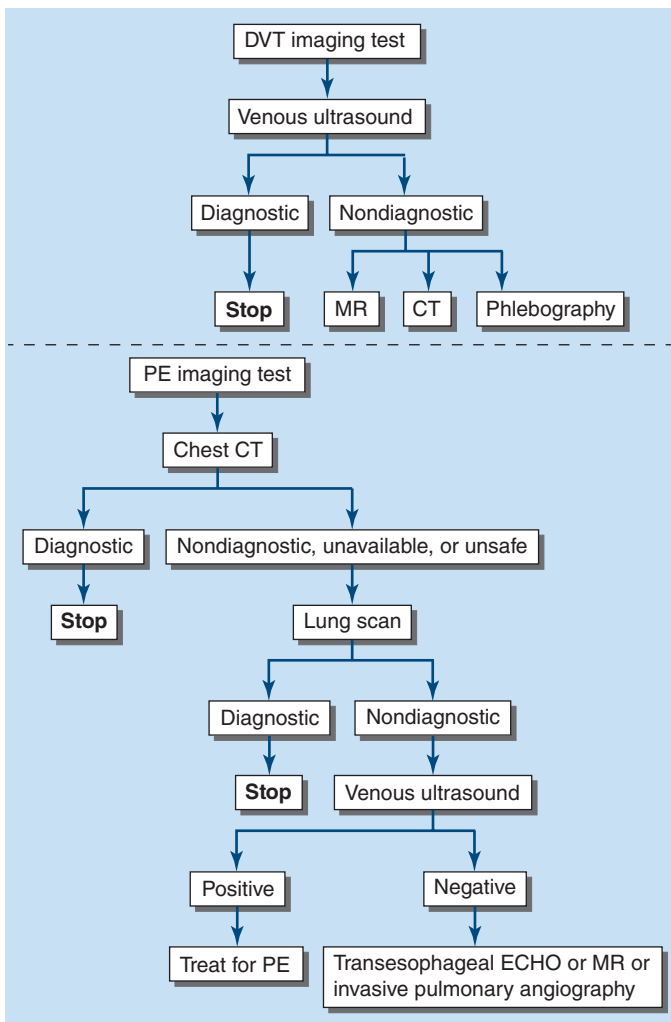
Integrated diagnostic approach. CT, computed tomography; DVT, deep-venous thrombosis; ECHO, echocardiography; MR, magnetic resonance; PE, pulmonary embolism.
